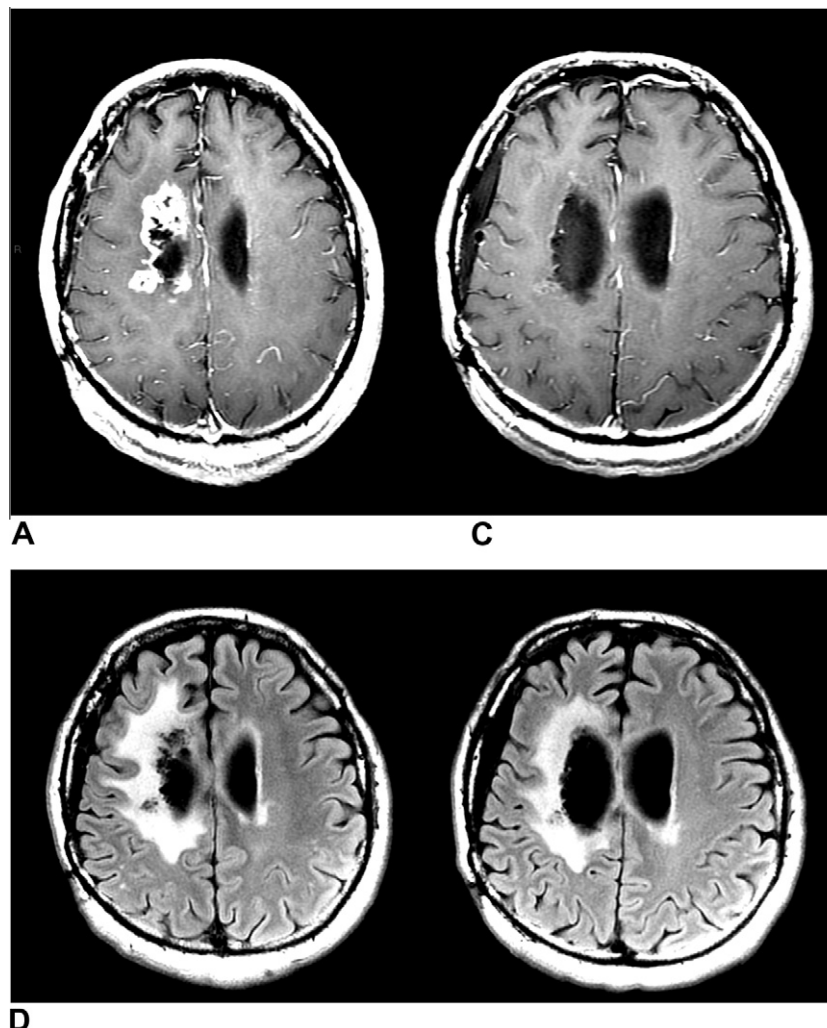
A disease response in a glioblastoma patient treated with bevacizumab. (A) baseline contrast-enhanced T1-weighted sequence, (B) baseline FLAIR sequence, (C) contrast-enhanced T1-weighted sequence after 6 cycles of bevacizumab 10 mg/kg every 2 weeks, (D) FLAIR sequence after 6 cycles of bevacizumab 10 mg/kg every 2 weeks.
